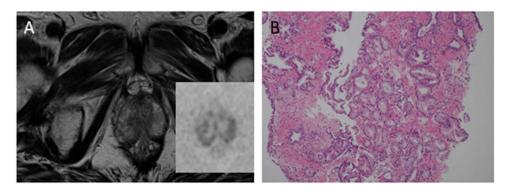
Images of multiparametric MRI and pathological diagnosis (A) Transverse T2-weighted and diffusion-weighted images. Multiparametric MRI indicated two PI-RADS 3 lesions, one in the left peripheral zone and the other in the right peripheral zone. The lesions were diffusely hypointense on T2-weighted images and showed moderately restricted diffusion. (B) Targeted biopsies taken from the left peripheral zone revealed Gleason grade 3+4 adenocarcinoma. Abbreviations: MRI, magnetic resonance imaging; PI-RADS, Prostate Imaging-Reporting and Data System.
